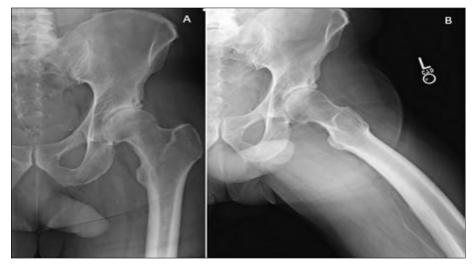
Anteroposterior (AP) (A) and Lateral (B) views of left hip in 2019. Radiographs demonstrate mild to moderate joint space narrowing of the left hip which is more pronounced superiorly with associated subchondral sclerosis as well as subchondral cysts within the lateral acetabular roof.
